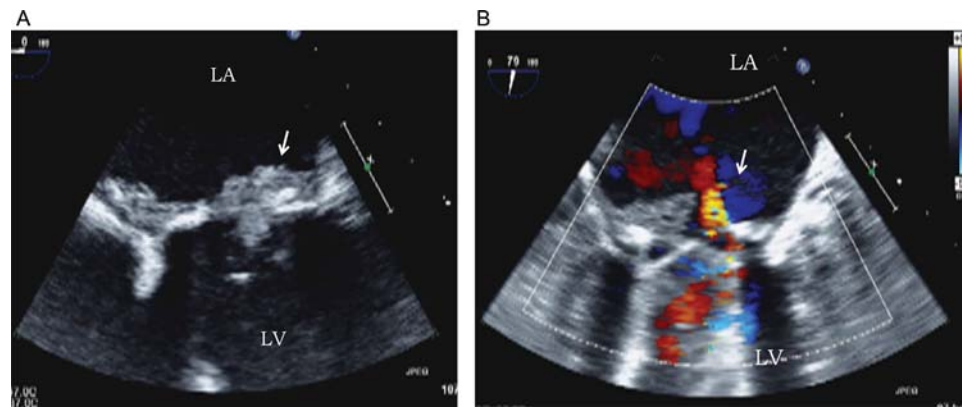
Mitral prosthetic valve endocarditis with prosthetic obstruction (transoesophageal echocardiography). (A) Large vegetation prolapsing into the mitral mechanical prosthetic valve (arrow). (B) Central regurgitation associated with the absence of the physiological regurgitant jets (arrow). LV, left ventricle; LA, left atrium; RV, right ventricle.
